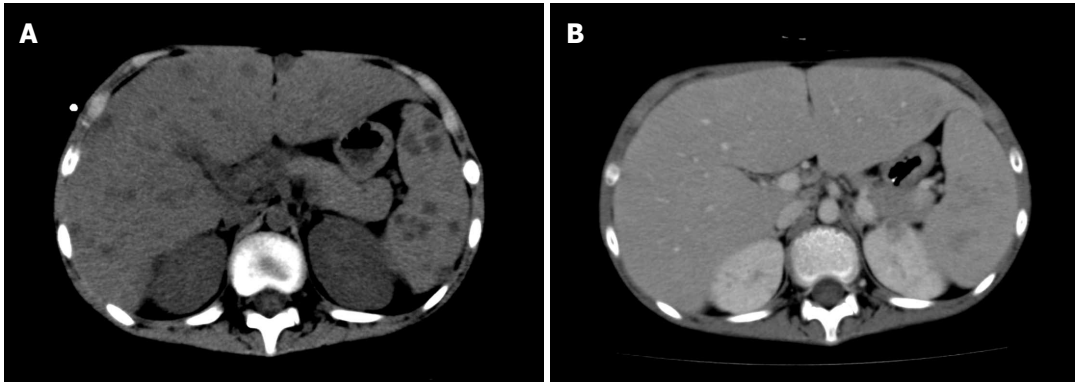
Computer tomography scan images of the liver. Computed tomography (CT) scans of the liver performed on the 51st (upper panel) and 239th d (lower panel) are presented. A: A simple CT scan; B: CT is enhanced.
